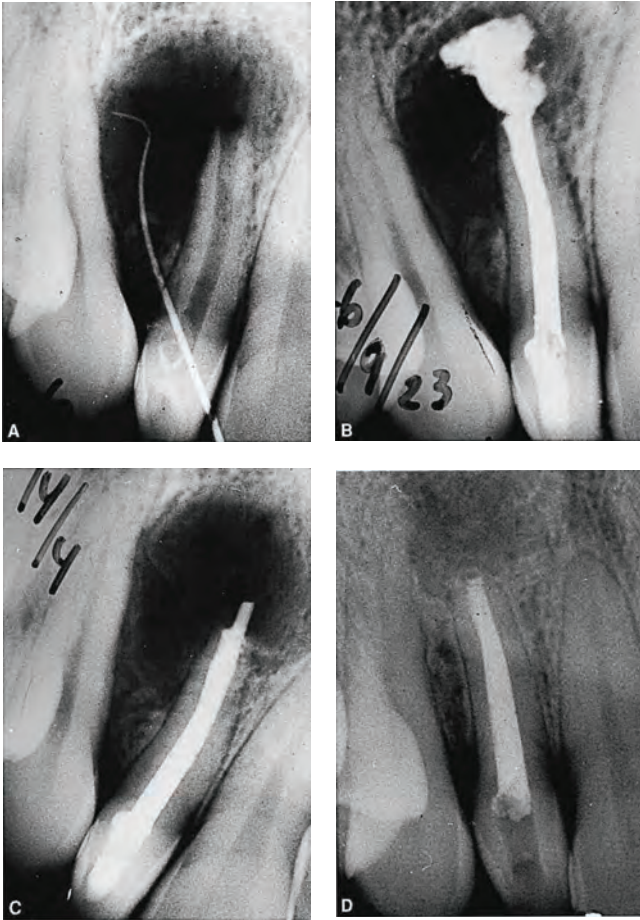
A, Dens invaginatus (dens in dente), with accompanying apical/lateral cyst. Gutta-percha sound is placed through a draining stoma. B, Calcium hydroxide and iodoform paste fills the débrided canal. C, The drainage ceased and $\text{Ca}(\text{OH})_2$ resorbed away in 8 months, at which time the canal was filled with gutta-percha and AH26 sealer (Dentsply/DeTrey) no surgery. D, Follow-up radiograph 15 years after obturation. Courtesy of C.C. Mexia de Almeida, Lisbon, Portugal.
